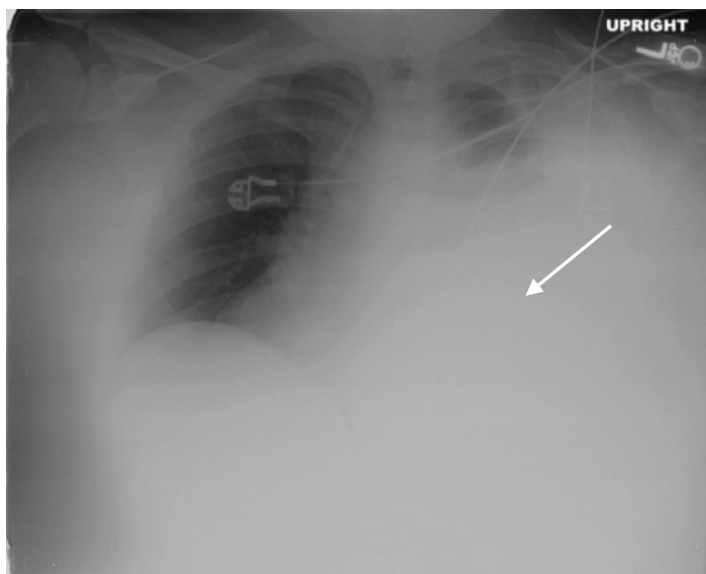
Anteroposterior chest radiograph demonstrating a dense left-sided opacity suggestive of intrathoracic gastrointestinal contents, with an associated mediastinum into the right hemithorax (arrow).
